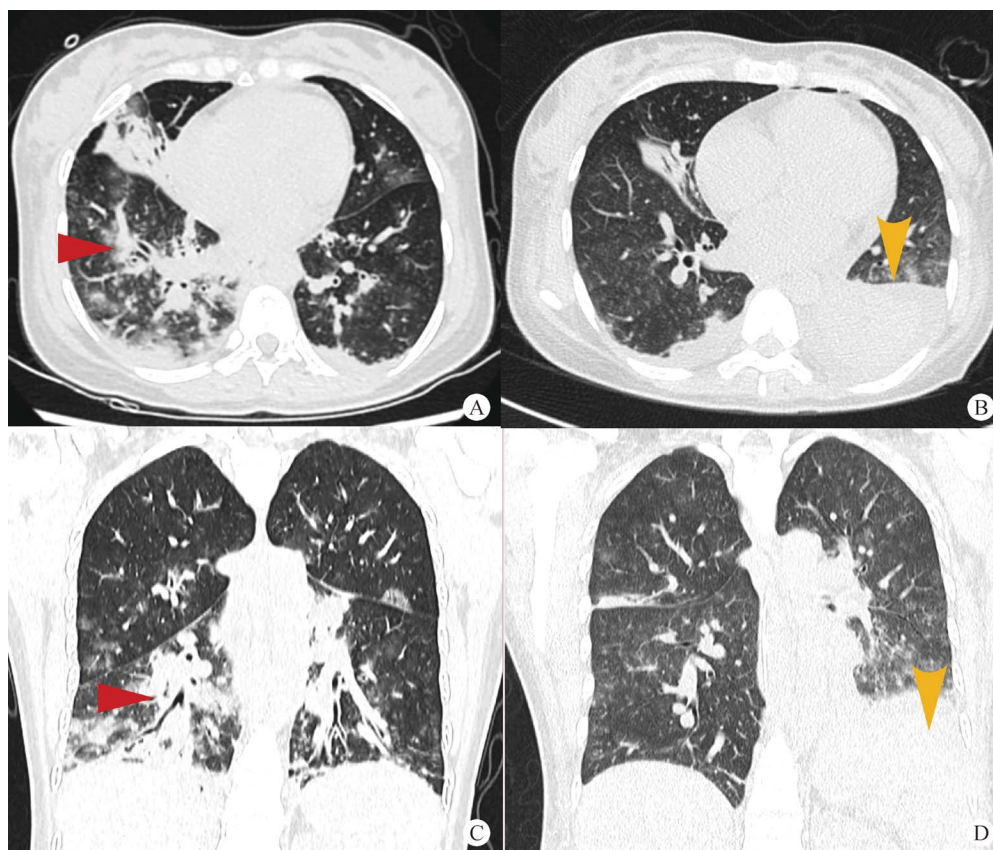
Chest CT image of a pregnant woman infected by COVID-19 before (A and C) and after (B and D) ECMO treatment. A (axial plane) and C (coronal plane) show bilateral ground glass opacities admixed with patchy areas of consolidation, especially in the right lower lobe (red arrow). B (axial plane) and D (coronal plane) show reduced ground glass opacities and consolidative changes in the right lower lobe after ECMO treatment but with extensive consolidation in the left lower lobe (yellow arrow). COVID-19: Coronavirus disease 2019; CT: Computed tomography; ECMO: Extracorporeal membrane oxygenation.
